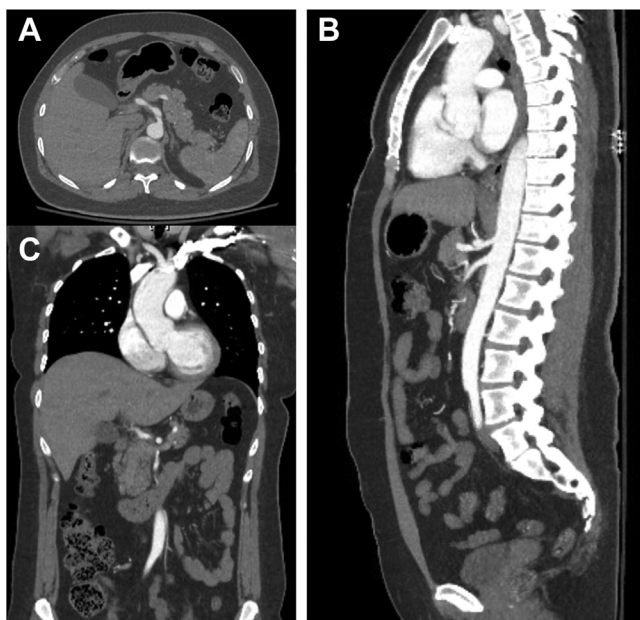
Postoperative axial (A), sagittal (B), and coronal (C) images of computed tomography angiography (CTA) performed 9 months after procedure showing minimal residual proximal celiac artery dissection with patent common hepatic artery and proper hepatic artery and resolution of dissection in the segment.
